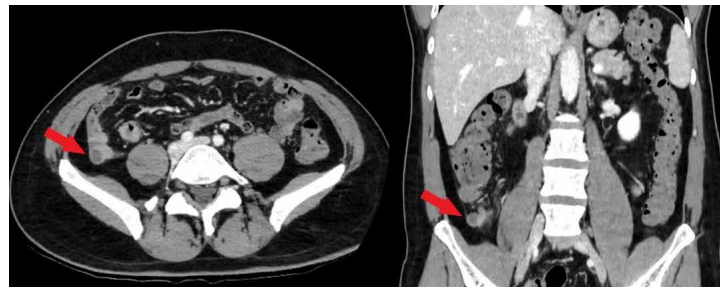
Axial (left) and coronal (right) CT scan on D10 demonstrating regression of the tissular infiltration and appendicitis, clearly depicting an appendicular diverticulum (red arrows)
